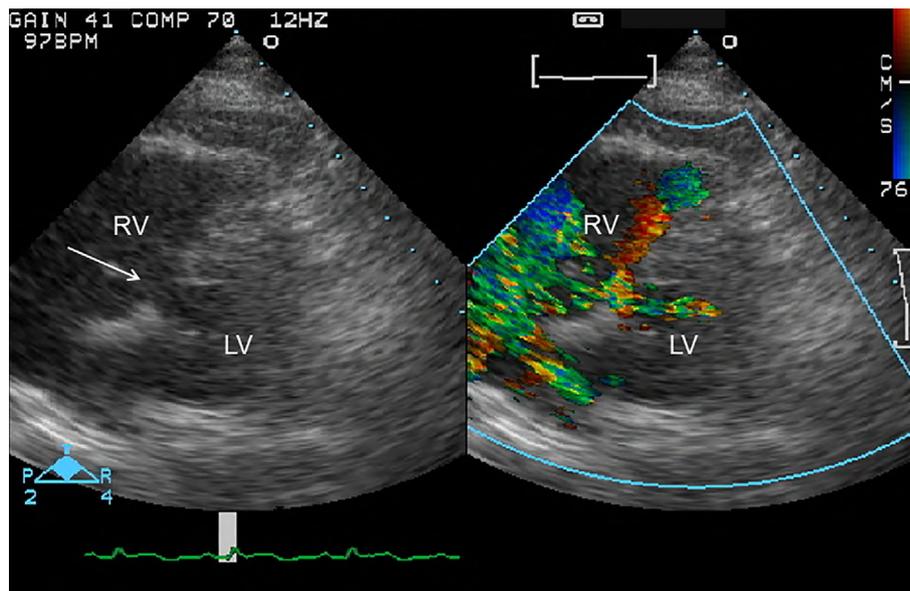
Transthoracic echocardiography performed on admission in the parasternal short axis view demonstrated a ventricular septal defect (white arrow) and a left-to-right ventricle shunt flow on color-flow Doppler imaging. LV: left ventricle, RV: right ventricle
